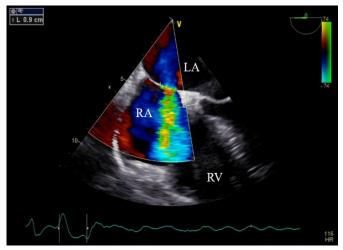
Mid esophageal view of interatrial septum with color flow doppler demonstrating left-to-right shunt across 0.9cm persistent iatrogenic septal defect. LA: left atrium, RA: Right atrium, RV: right ventricle
